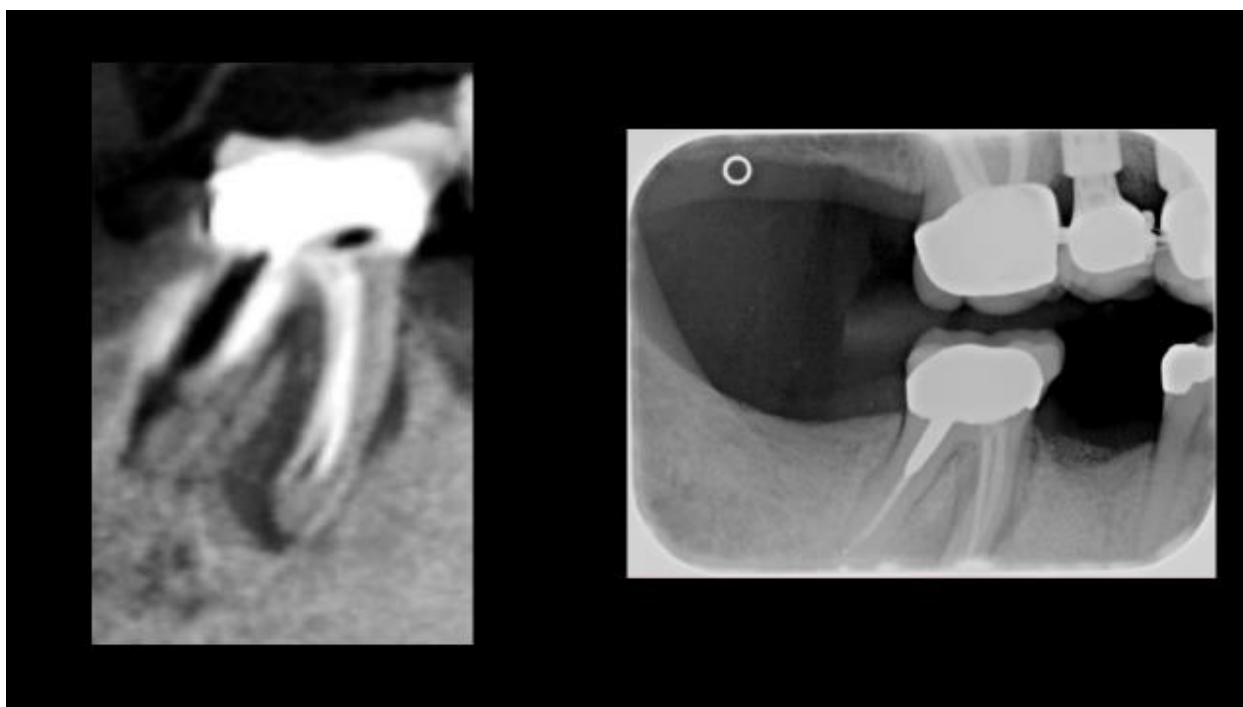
Indirect root fracture #30 CBCT (left) visible on PA (right)
